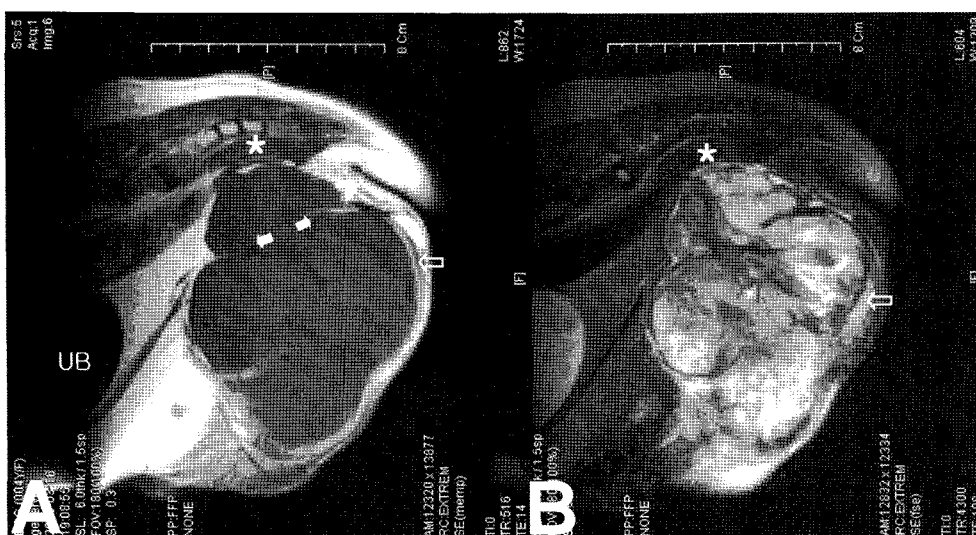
MRI findings: A, On T1-wighted image (TR/TE, 516/14), a mass has heterogenous signal intensity with similar to circumferential muscle (blank arrow). B, On T2-weighted image (TR/TE, 4300/95), this mass shows higher or similar to muscle, or lower than fat signal intensity. A nodular and well-circumscribed mass is seen in the pelvic cavity through the obturator foramen (white arrows). The rectum (*) is displaced dorsally by the mass in the pelvic cavity.
